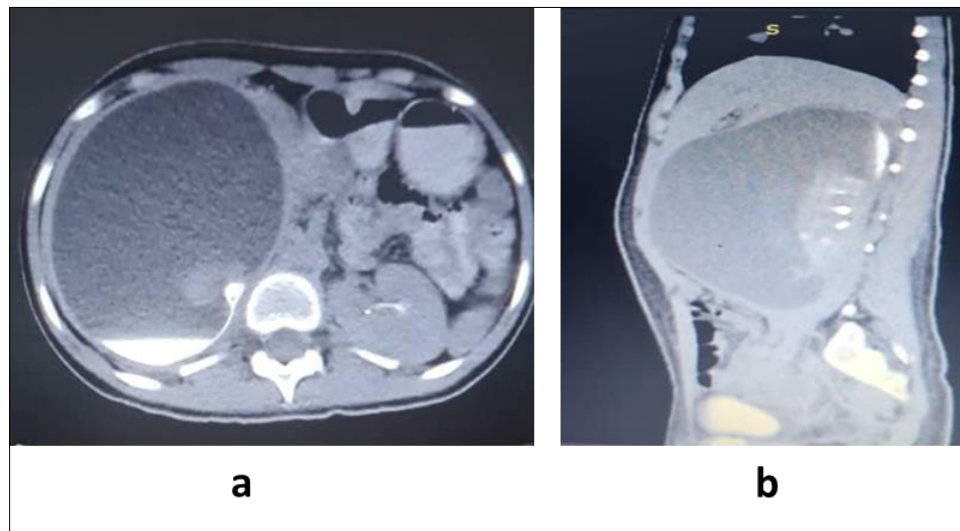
and 1b are contrast enhanced computed tomography(CECT) axial and sagittal views respectively showing the connection of the calyceal diverticulum with the pelvis
